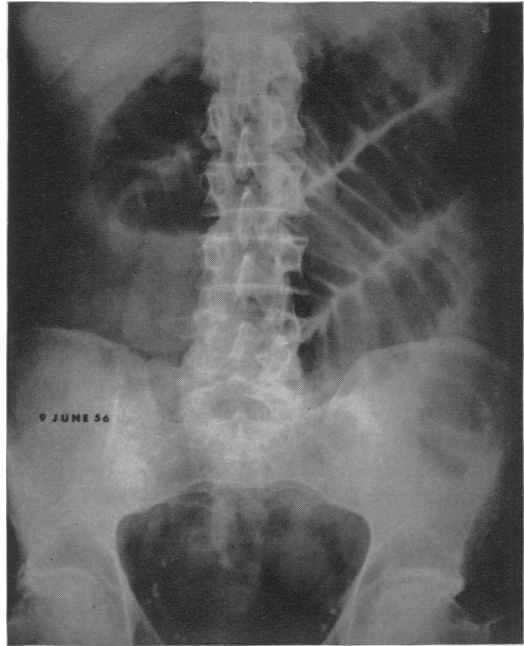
Roentgenogram of the abdomen revealing dilated jejunal loops performed at 1:00 a.m., June 9, 1956. The diagnosis of small bowel obstruction of a high degree is obvious.
